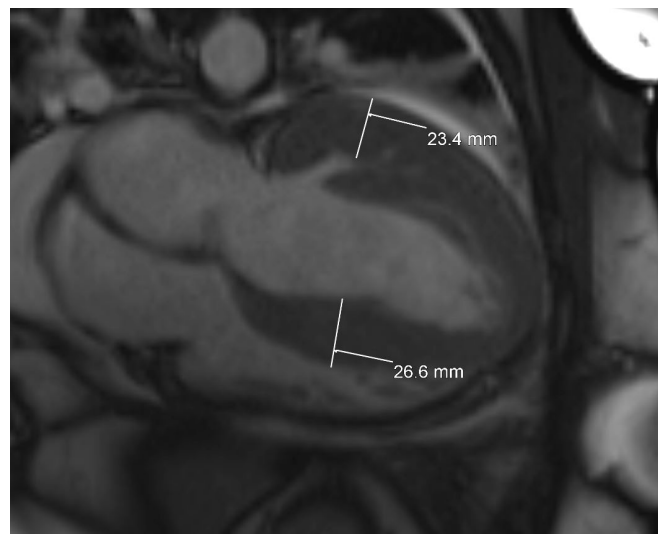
Cardiac MRI with hypertrophic cardiomyopathy.
